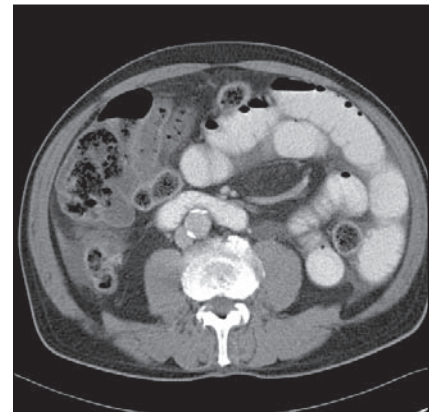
Abdominal computed tomography scan after oral and intravenous contrast application.
